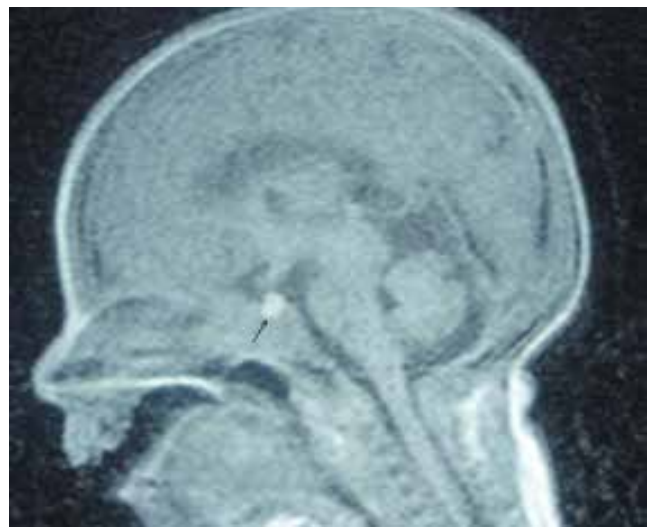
Pituitary MRI of the patient: the arrow shows hemorrhage in the posterior hypophysis
